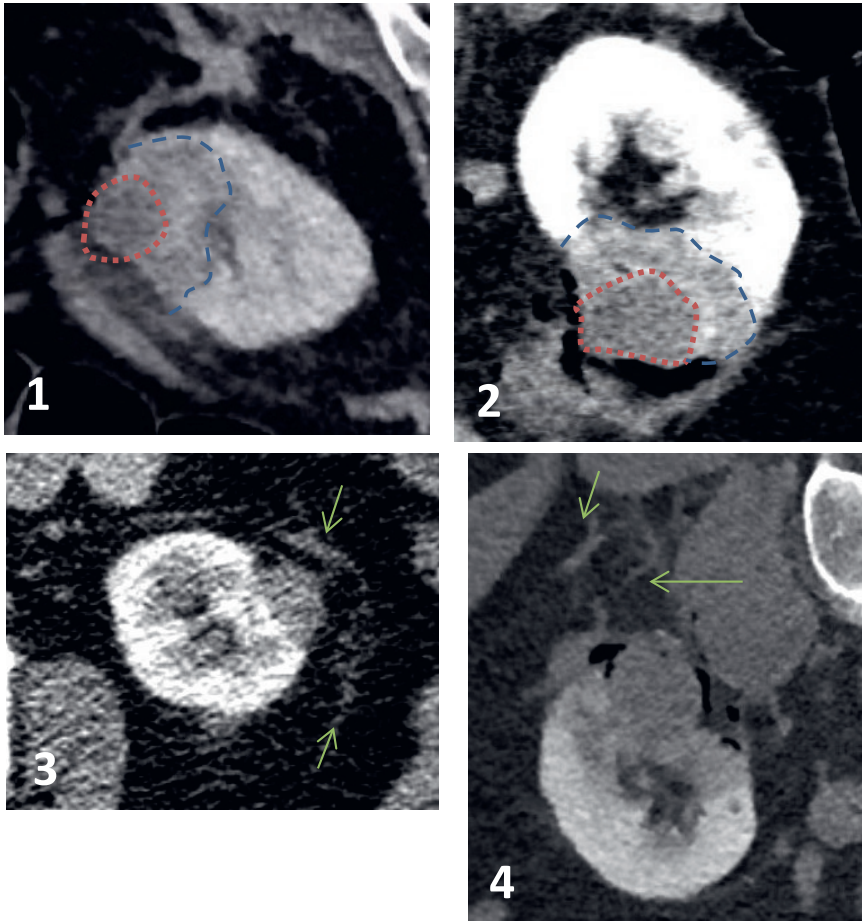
CT effects of IRE perioperatively. 1 en 2: CT scan performed perioperatively in SRM 10 and 6 respectively. Red lining indicates the hypodense ablated tumour. Blue lining indicates the oedematous and inflammation tissue surrounding it, also hypodense but less grey. 3: CT scan performed 3 months post-IRE in SRM 8. Green arrows indicate the perinephric stranding. 4: CT scan performed perioperatively in SRM 5. Green arrows outlining the perinephric stranding.
